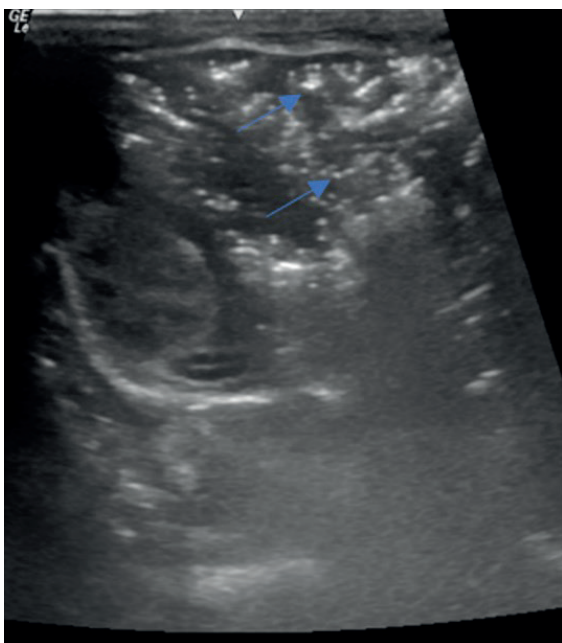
Ultrasonography revealed intense air echoes in the intestinal wall and portal system (blue arrows).
